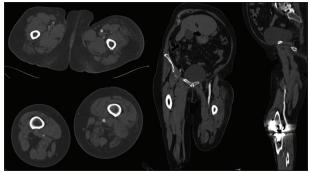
CTA at 6-month follow-up after aspirational thrombectomy and stenting.
